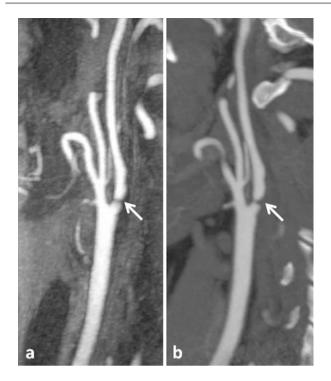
(a) Contrast-enhanced MRA performed with 3D T1-weighted sequences after injection of contrast medium shows the presence of a tight stenosis at the base of the internal carotid artery (*arrow*). CTA findings (b) are superimposable to that of MRA (*arrow*)
